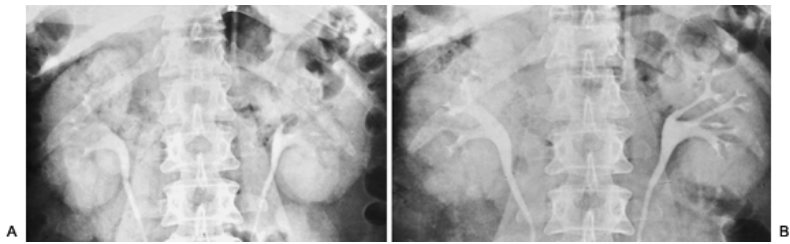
18. A: Radiograph taken 5 minutes after contrast injection demonstrates the pyelogram phase with opacification of the collecting system and proximal ureters. B: Radiograph following the use of a compression device in the same patient. Note distention of collecting systems with improved visualization of the calyces and infundibula.
